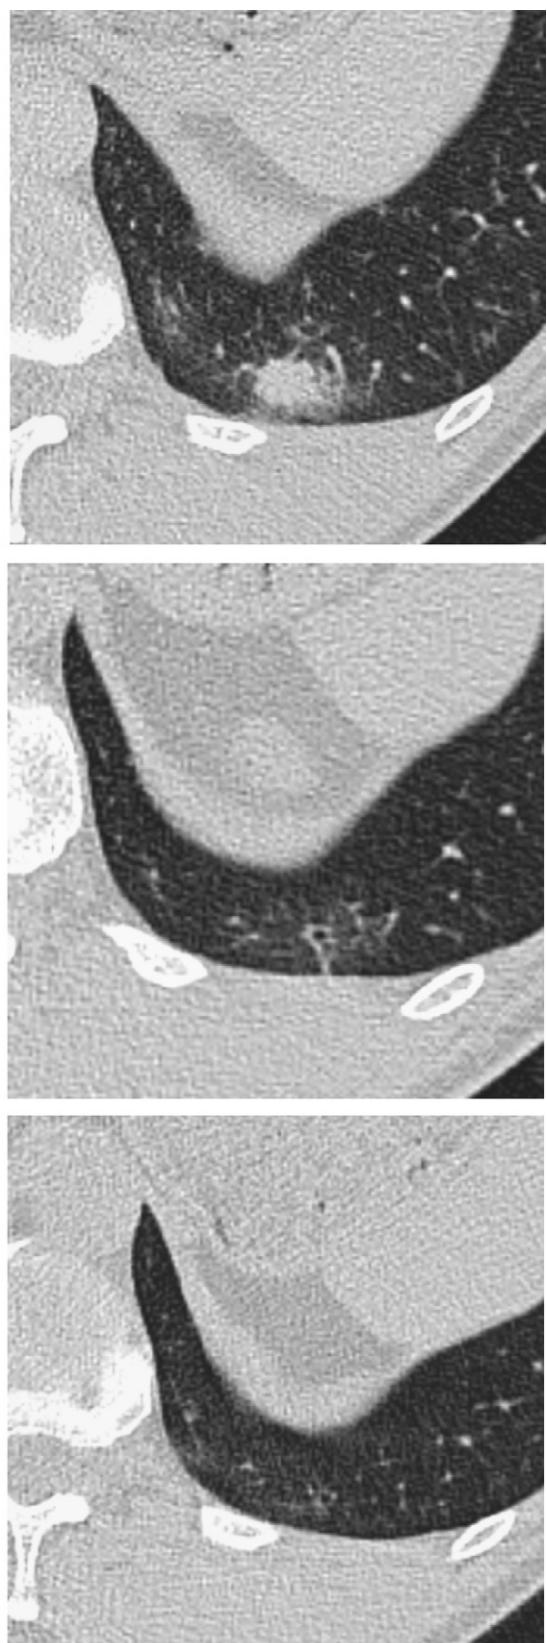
A 52-year-old man with a history of cigarette smoking and a history of head and neck cancer. (a) Transverse high-resolution CT scan shows a 22-mm oval mixed ground-glass opacity in the left lower lobe, with a predominant solid pattern, slightly irregular and convex margins. (b) Two months later: the density changes from mixed to pure ground-glass opacity. (c) Seventeen months later: the lesion is completely resolved.
